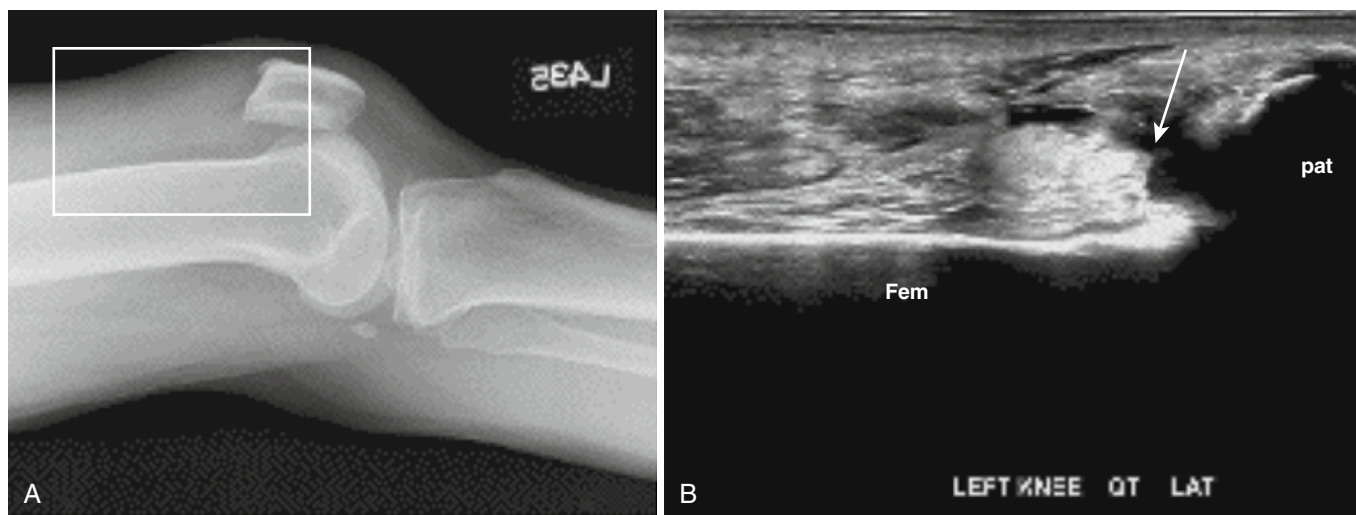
Radiograph (A) with inset shows a torn distal quadriceps tendon with loss of fibrillar pattern and a hypoechoic hematoma (arrow) on ultrasound (B).
